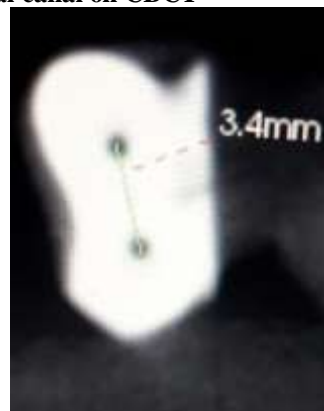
showing axial view of mesial root on CBCT
